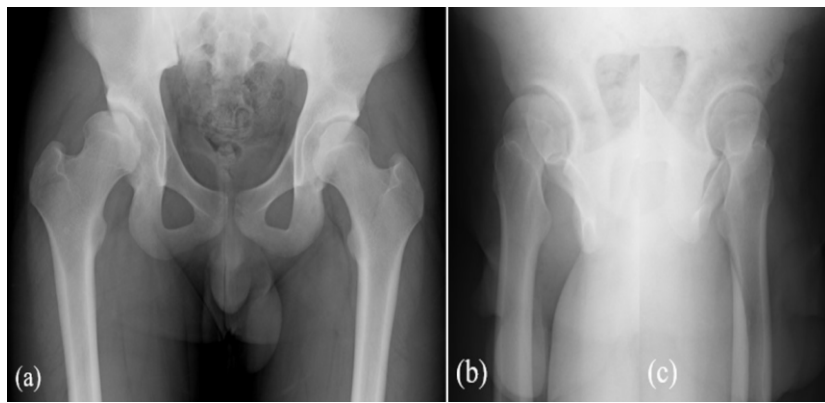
X-ray images at the first visit to our department. Depressed deformity of the right femoral head loading portion could be seen. Bilateral acetabular dysplasia was diagnosed, too. (a) AP view of the hip joints (b) Right false profile view (c) Left false profile view
